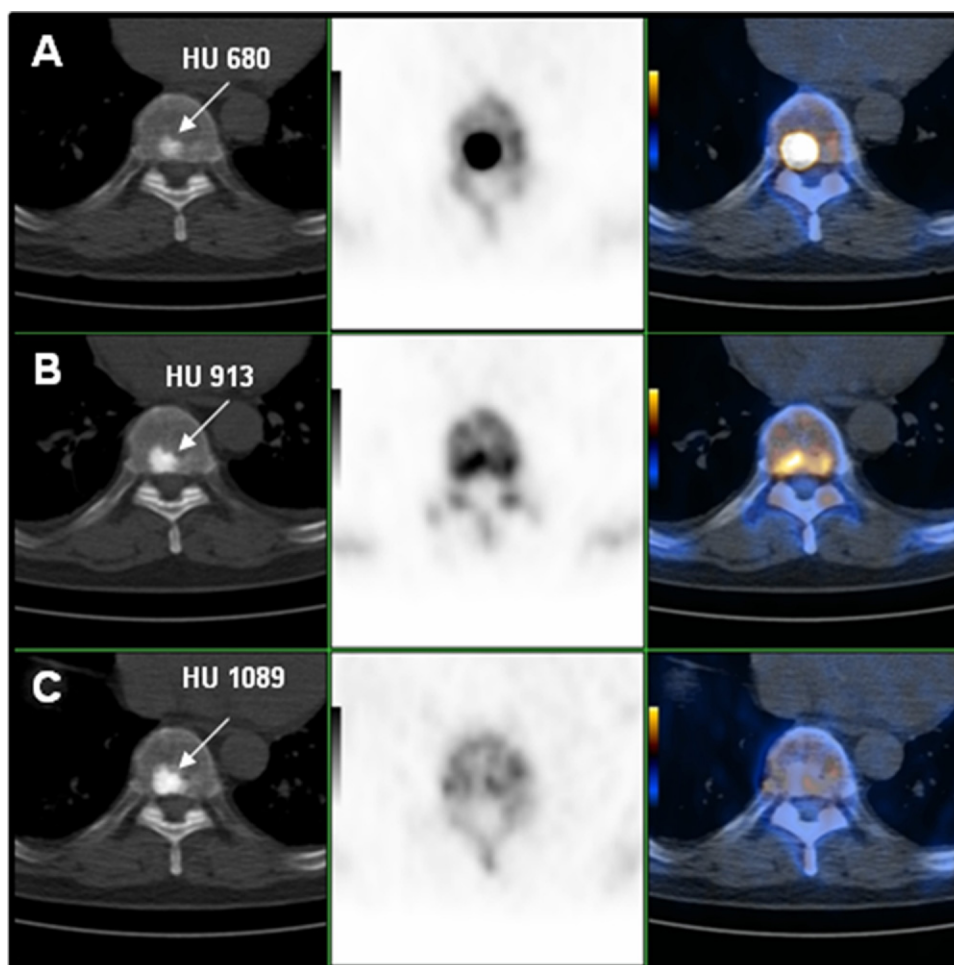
BM detected by ^{18}F -fluoride PET/CT under HT. (A) Osteoblastic changes (fluoride-positive, CT-positive). (B) Increasing density of sclerotic lesion with decreasing intensity of fluoride. (C) Highly dense sclerotic lesion without metabolic activity in fluoride PET study.
